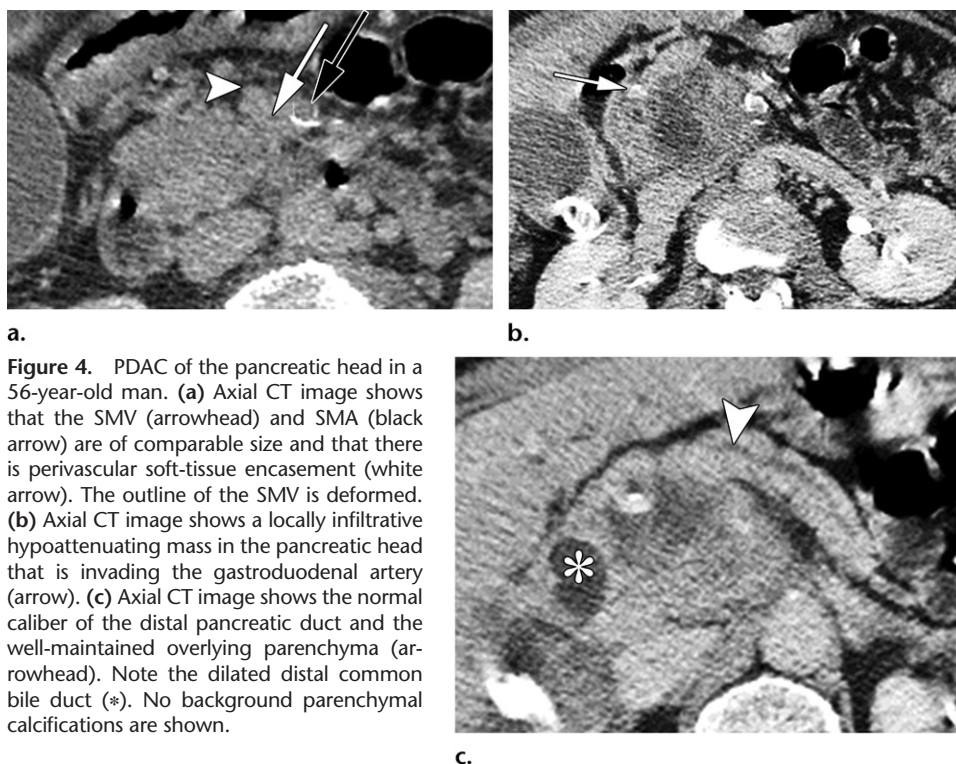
PDAC of the pancreatic head in a 56-year-old man. (a) Axial CT image shows that the SMV (arrowhead) and SMA (black arrow) are of comparable size and that there is perivascular soft-tissue encasement (white arrow). The outline of the SMV is deformed. (b) Axial CT image shows a locally infiltrative hypoattenuating mass in the pancreatic head that is invading the gastroduodenal artery (arrow). (c) Axial CT image shows the normal caliber of the distal pancreatic duct and the well-maintained overlying parenchyma (arrowhead). Note the dilated distal common bile duct (*). No background parenchymal calcifications are shown.
